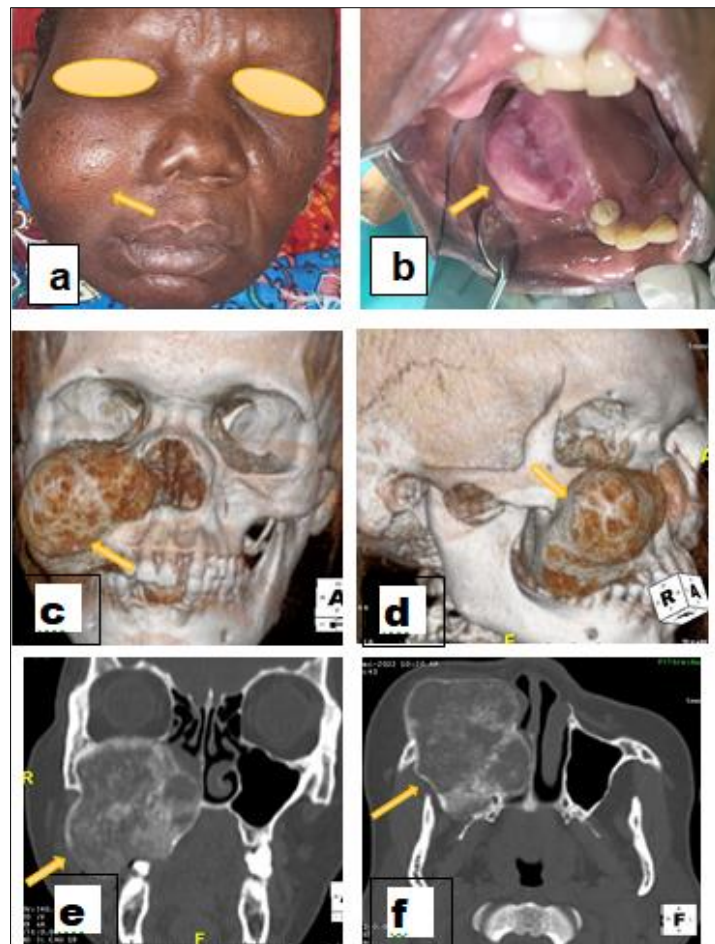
Ossifying fibroma of the right maxilla in a 47-year-old woman. a – Exobuccal view; b – Endobuccal view; c-d-e-f (CT scan): c-d-3D reconstruction (anterior-posterior and 15 o'clock views), e-coronal section; f-axial section
